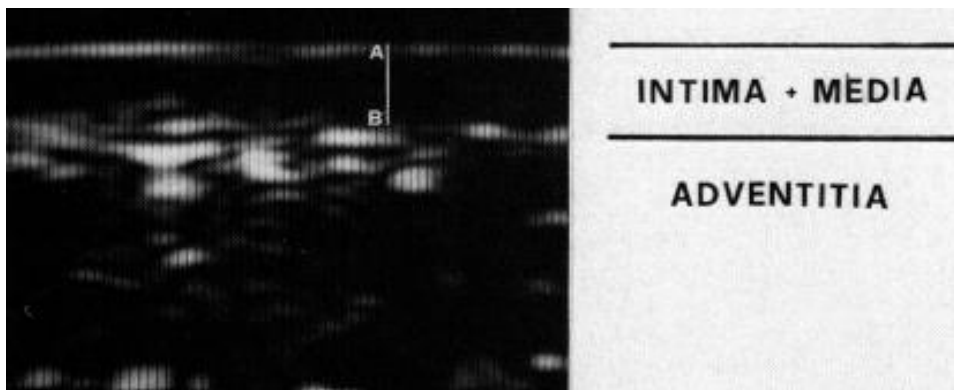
First reported use of ultrasound to produce a B-mode image the typical appearances of a normal carotid arterial wall. The A-B line represents the distance between the inner and the outer echogenic lines and corresponds to the B mode image of intimal + medial thickness (Reproduced from Pignoli et al¹⁴)
